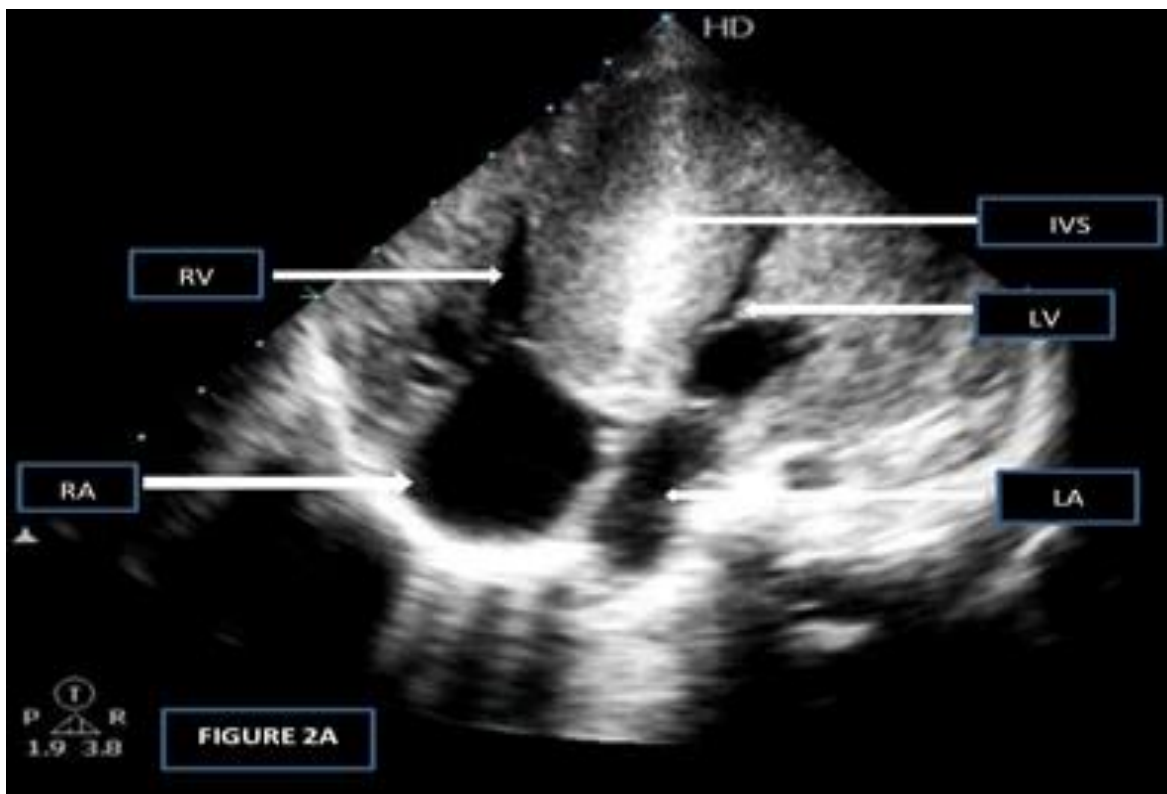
Apical 4-chamber view showing marked biventricular hypertrophy with thick interventricular septum. LA: Left atrium, LV: Left ventricle, RA: Right atrium, RV: Right ventricle, IVS: Interventricular septum.
